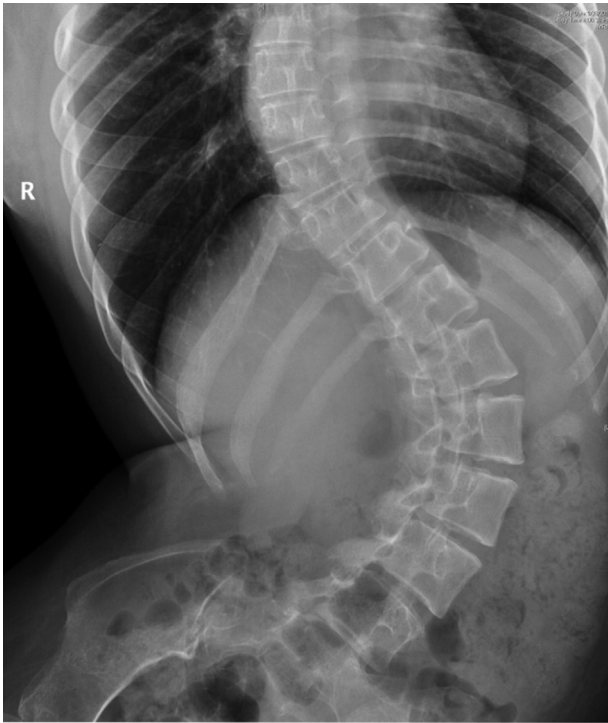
Plain X-ray of the thoracolumbar spine taken in anteroposterior view showing severe scoliosis.
